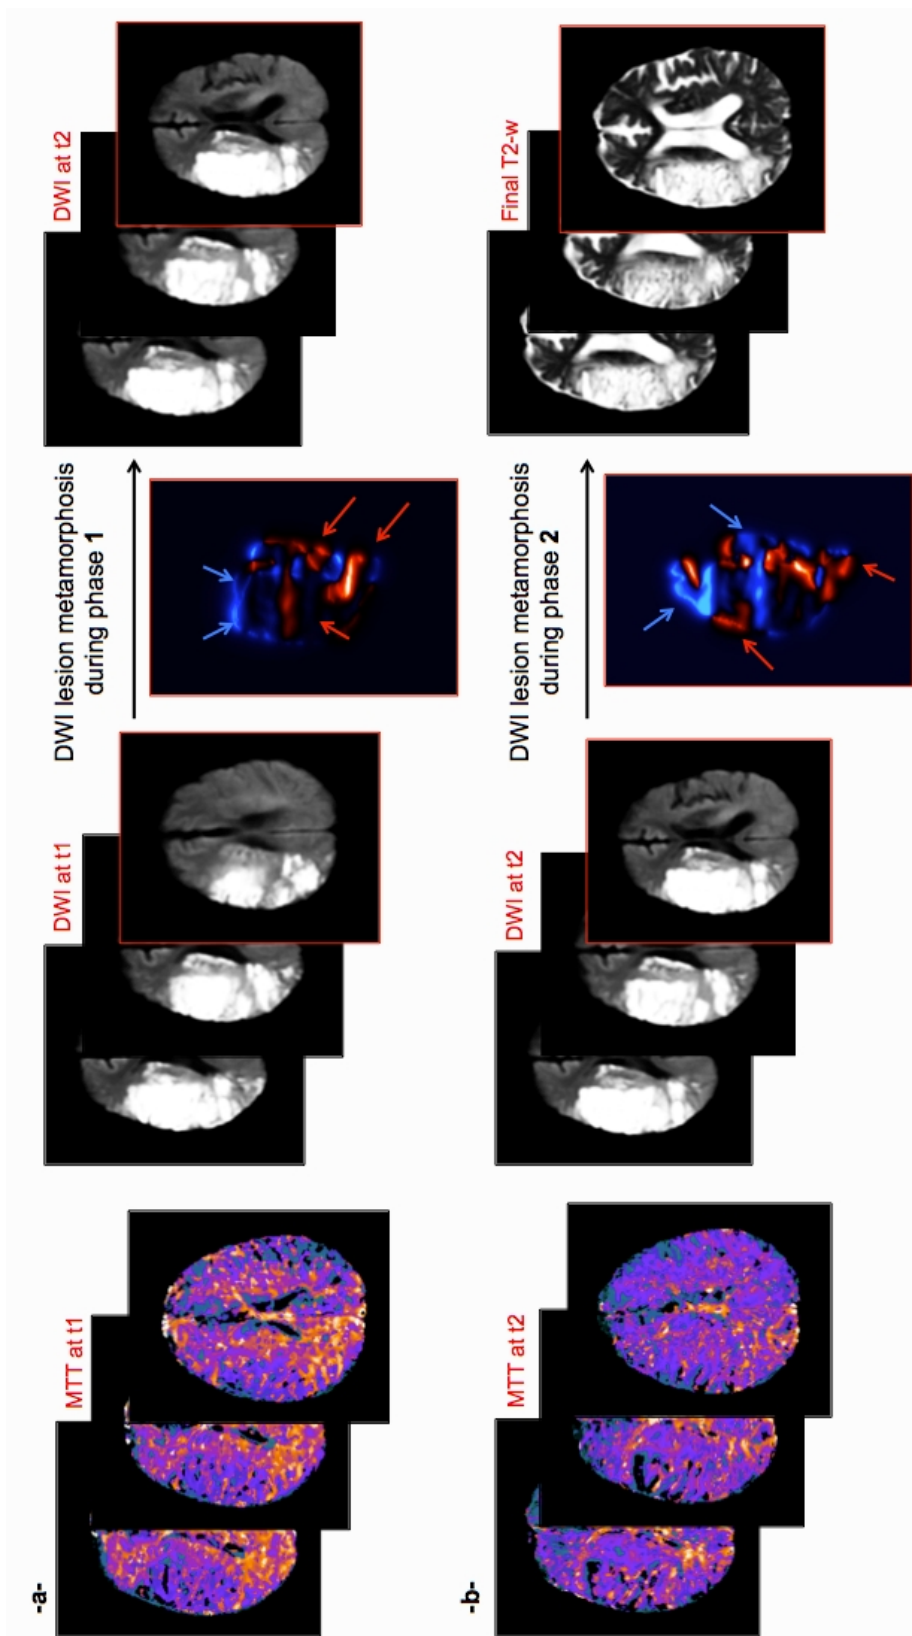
(a) Axial slices of acute MTT image (left), acute DWI image (middle) and subacute DWI image (right). (b) Axial slices of subacute MTT image (left), subacute DWI image (middle) and final T2-w image (right). During phase 1, we metamorphose DWI lesion at t_1 to DWI lesion at t_2 . During phase 2 we deform the latter into final T2-w lesion. We estimate the deformation maps for phase 1 and phase 2 of DWI lesion evolution (images under the black arrows). The red arrows point to highly expanding areas and blue arrows point to highly contracting areas.
